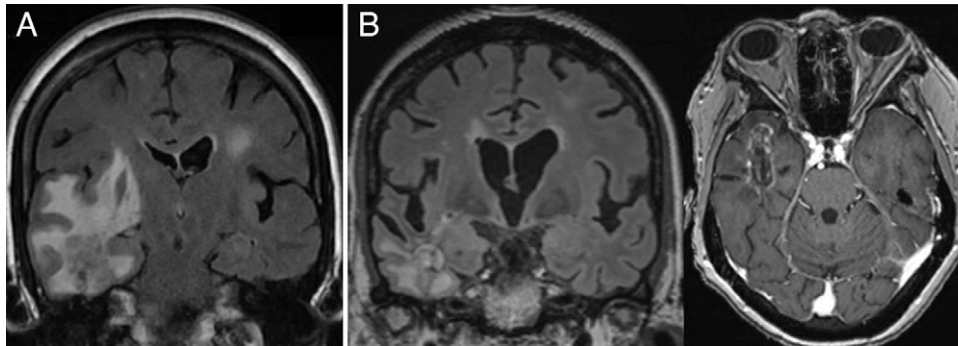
A: Coronal fluid-attenuated inversion recovery (FLAIR) MRI showing the right temporal glioblastoma before LITT. B: Coronal FLAIR (*left*) and axial postcontrast T1-weighted (*right*) magnetic resonance images showing the right temporal glioblastoma 6 months after LITT and Stupp protocol.
